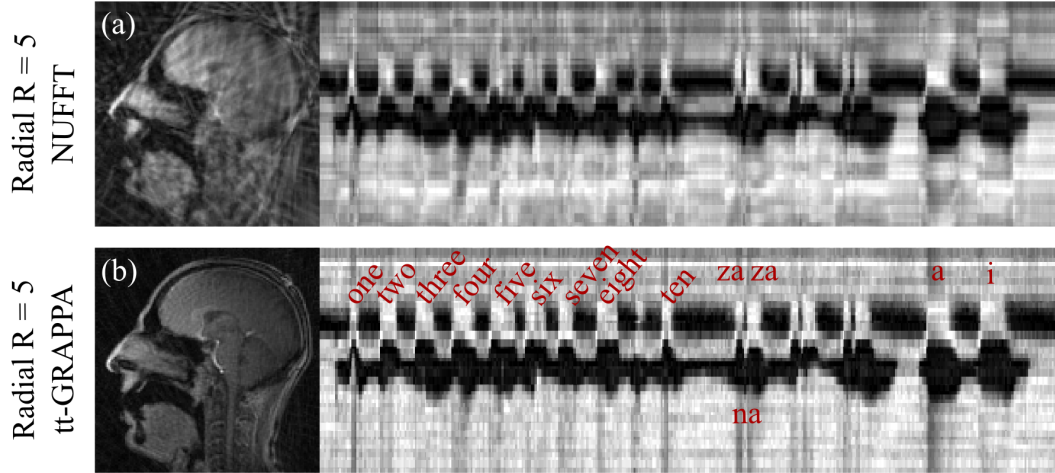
shows real-time speech MRI of two subjects repeating the selected speech task, acquired with accelerated radial  $R = 5$  (91 ms per frame) and reconstructed with zero-filled NUFFT (Figure 6.5 a,c) and tt-GRAPPA (Figure 6.5 b,d). Zero-filled NUFFT reconstruction showed increased image distortion due to aliasing (i.e. insufficient sampling of k-space data). In the case of radial trajectories, aliasing translates into sharp spoke-like artefacts in the final reconstructed image. On the other hand, reconstruction of the same data sets with tt-GRAPPA (through-time calibration:  $1 \times 1 \times 200$ ) provided imaging data with diminished aliasing artefacts present and clear definition of the vocal tract articulators. Additionally, it also demonstrated adequate temporal depiction of velopharyngeal motion as a clear identification of expected velopharyngeal closures corresponding to phonation sounds was possible in the intensity-time profiles (Figure 6.5 b).
